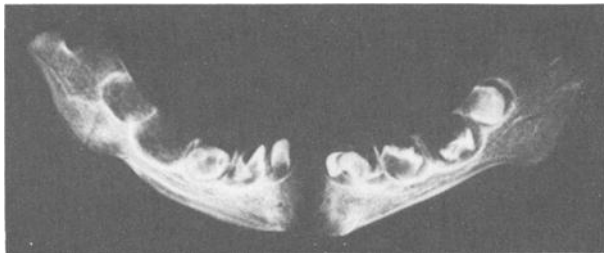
Radiograph of mandible of Body C showing antemortem healing unilateral fracture.
